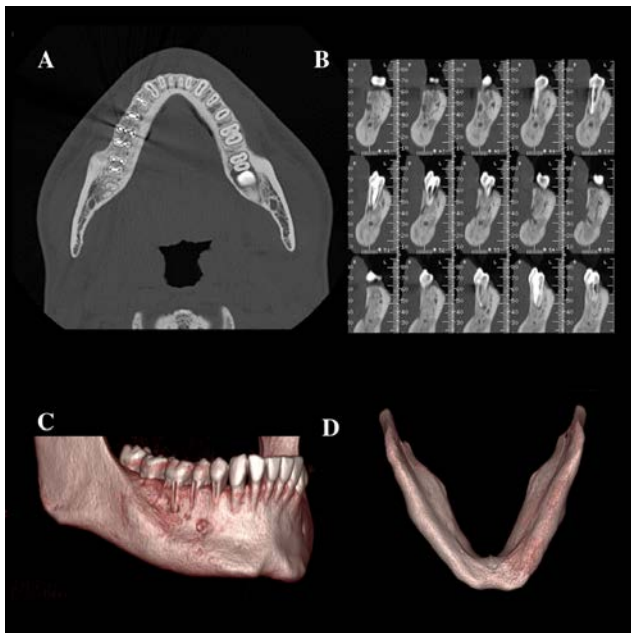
CBCT after seven months of follow-up; clear signs of remission can be noted
